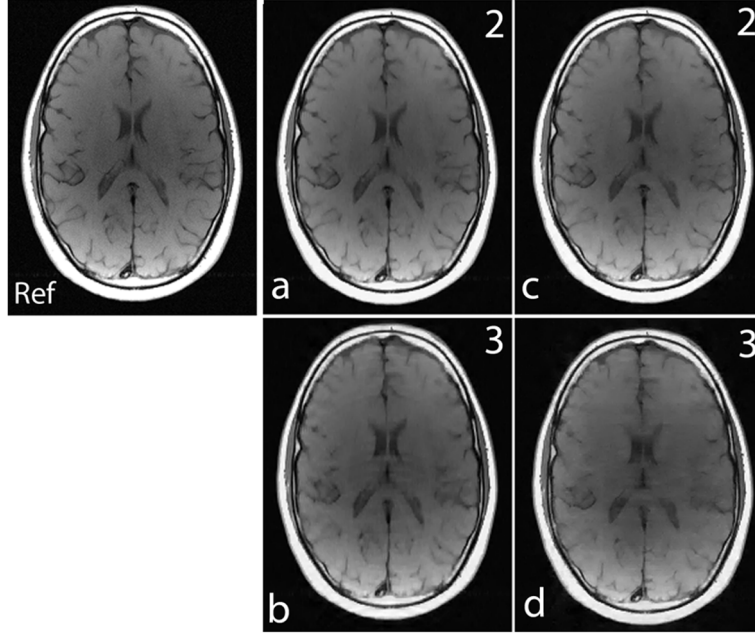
Ref: represents the reference image 256×256 (up/down: phase encodes, left/right: frequency encode); (a)-(b): show images reconstructed using Fourier encoding with variable density random under-sampling patterns for acceleration factors of 2 and 3 respectively; (c)-(d): show images reconstructed using noiselet encoding with completely random under-sampling patterns for acceleration factors of 2 and 3 respectively. Noiselet encoded CS-MRI performs better than the Fourier encoded CS-MRI when completely random under-sampling is used for both the encoding schemes. This is due to the better incoherence provided by the noiselets. However, noiselet encoding with a random under-sampling pattern performs similar to Fourier encoding with a variable density random under-sampling pattern.
